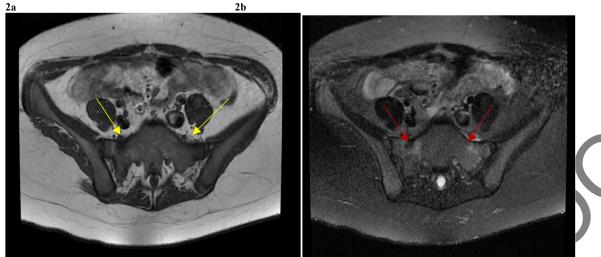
Axial MR images of the patient demonstrate bone marrow edema within the bilateral sacral alae, characterized by hypointense signals on T1-weighted sequences (yellow arrows, 2a) and hyperintense signals on T2-weighted sequences (red arrows, 2b).
